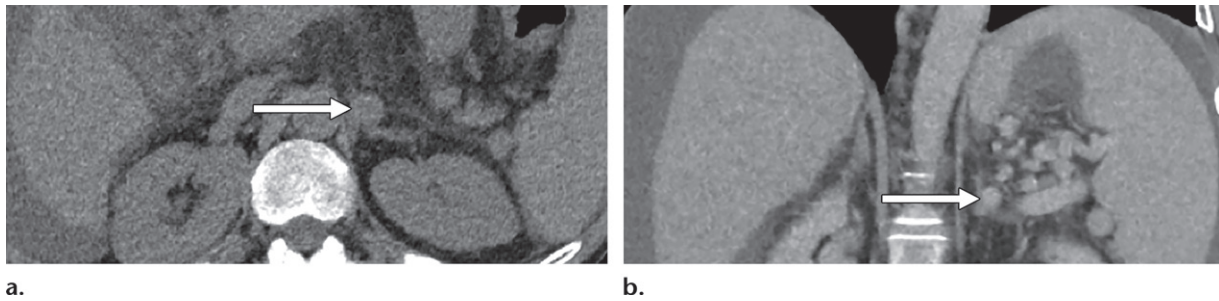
Vascular mimics of adrenal pathologic conditions. (a) Axial nonenhanced CT image shows a suspected left adrenal nodule (arrow) in a patient with cirrhosis and radiologic features of portal hypertension (splenomegaly, ascites, and varices). Contrast enhancement of the left adrenal nodule follows that of the venous system. (b) Coronal portal venous phase reconstructed CT image shows the abnormality to be a splenic varix (arrow). Dilated, tortuous, or aneurysmal vessels may extend into the suprarenal space and mimic adrenal pathologic conditions.
